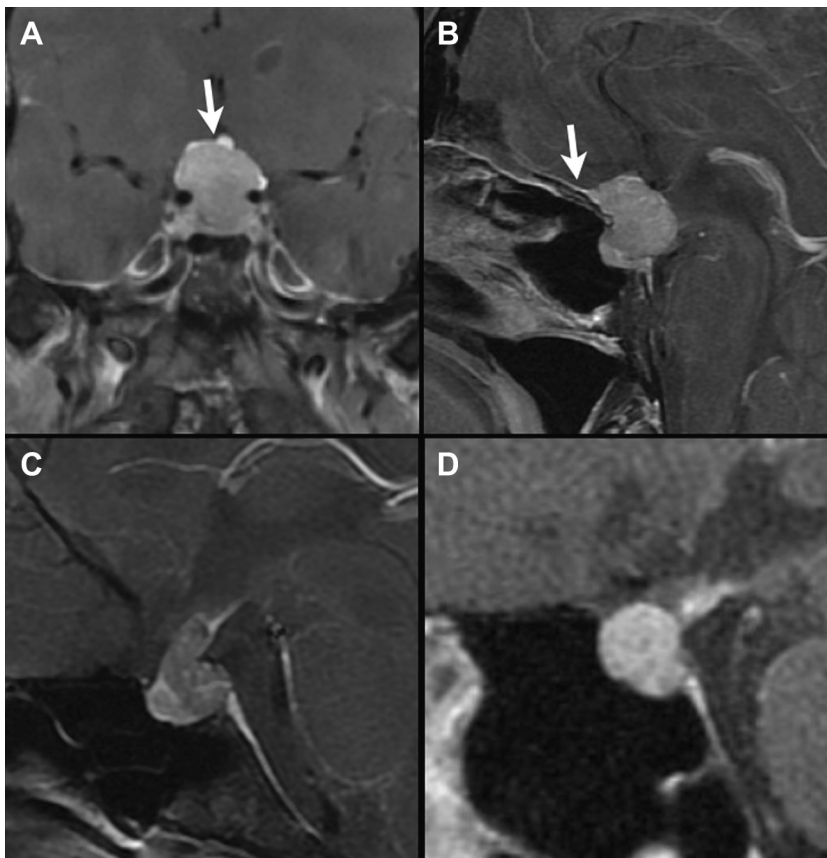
Macroadenoma mimics. Coronal (A) and sagittal (B) gadolinium-enhanced T1-weighted images showing sellar and suprasellar mass with portions of the residual pituitary displaced superiorly by the mass (A, arrow) and anterior dural tail along the planum sphenoidale (B, arrow). Breast (C) and bronchogenic (D) carcinoma metastatic disease may also mimic adenoma.
